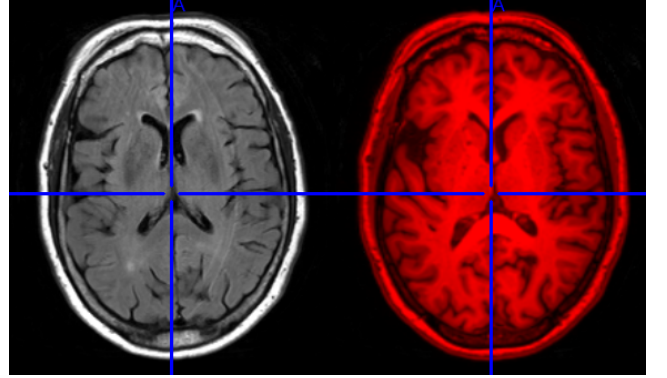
MPRAGE and FLAIR image overlaid. Left image, the T1 weighted MPRAGE. Right in red, the overlaid FLAIR over the T1.
